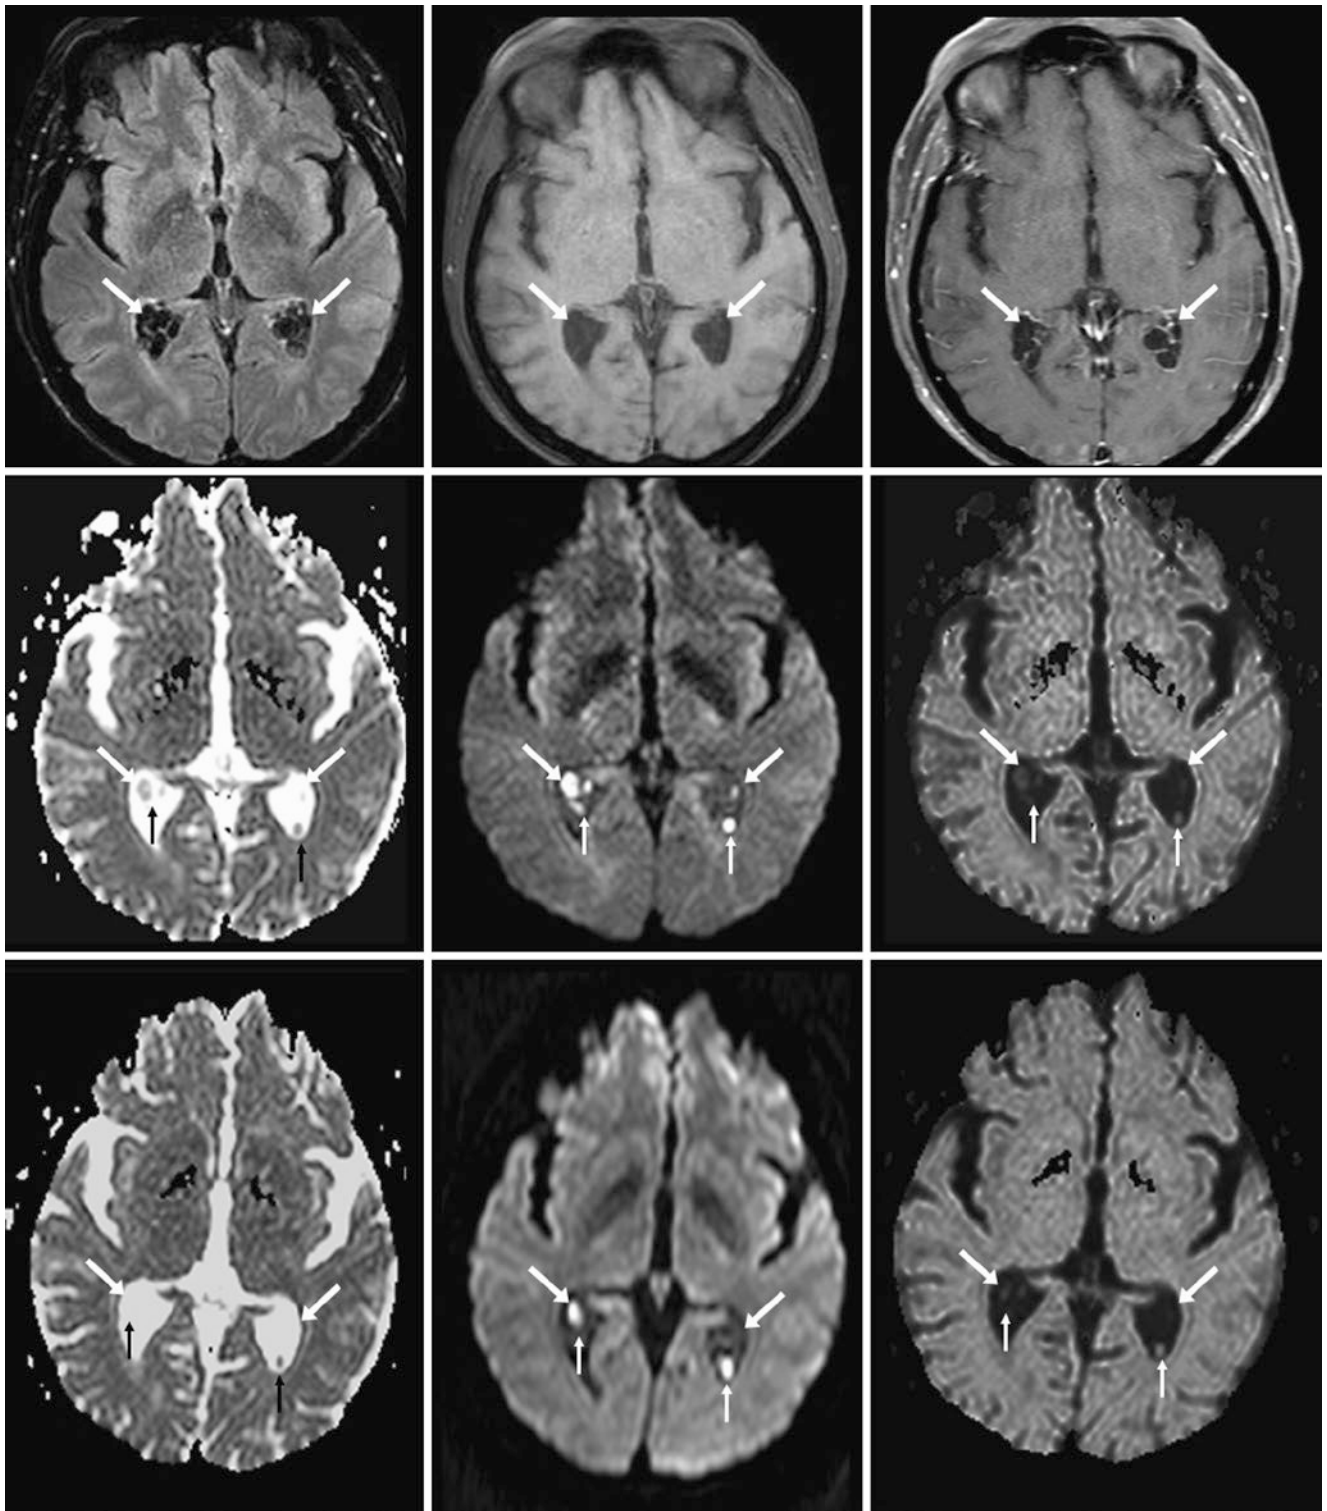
Choroid plexus xanthogranuloma (CPXG). A 74 year old underwent a 1.5 T MRI to evaluate for infarct (negative examination). *Top row:* there were bilateral CPXGs (*arrows*) noted on axial postcontrast FLAIR (*left*; note the enhancing septae of the CPXG), noncontrast T1WI (*middle*), and postcontrast T1WI (*right*). *Middle row:* The reduced diffusivity is inhomogeneous on the ADC map (*left*) and DWI
